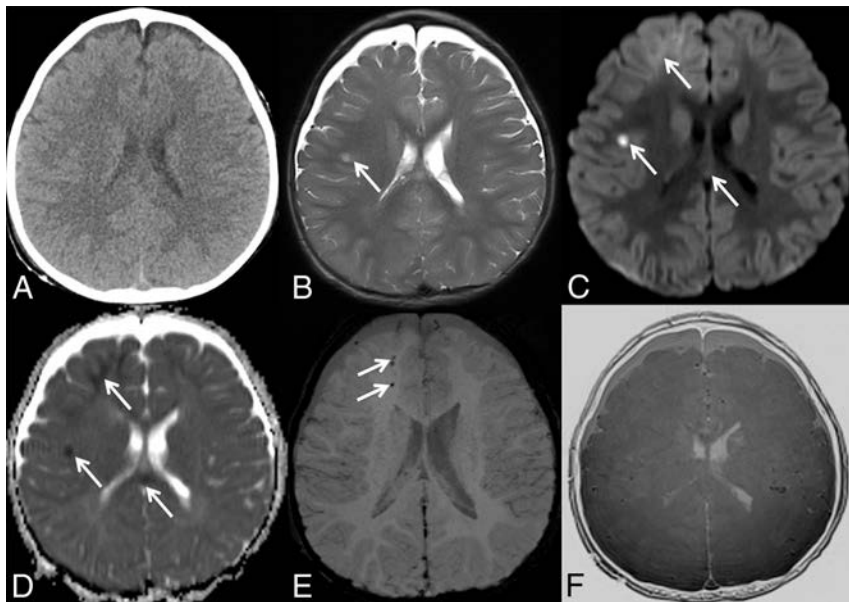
A, Axial CT image does not show intracranial hemorrhage. A matching axial T2-weighted MR image (B), axial trace of diffusion (C), ADC map (D), minimal intensity projection-SWI (E), and inverted black bone MR image (F) reveal areas of T2-hyperintense signal and restricted diffusion within the temporal white matter (arrows in B–D), areas of restricted diffusion within the right frontal lobe and splenium of the corpus callosum (arrows in C and D), and foci of hypointense SWI signal within the right frontal white matter (arrows in E), suggestive of intracranial hemorrhages and diffuse axonal injury not seen on axial CT.
